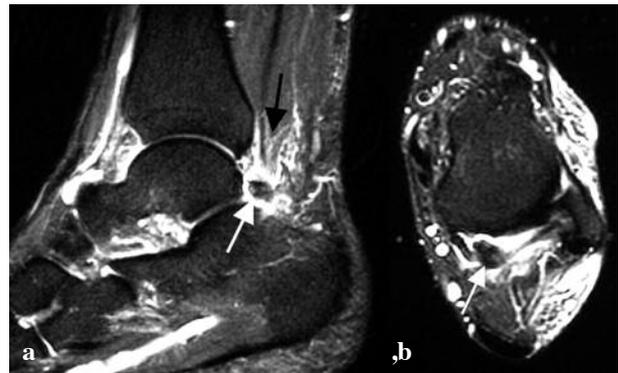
MRI showing flexor hallucis longus abnormality in PAIS - (a) Sagittal STIR and (b) Axial T2-weighted images showing os trigonum with surrounding inflammation and fluid in the posterior synovial recess indicating synovitis. This inflammation extends along the flexor hallucis longus (FHL) tendon (black arrow).
